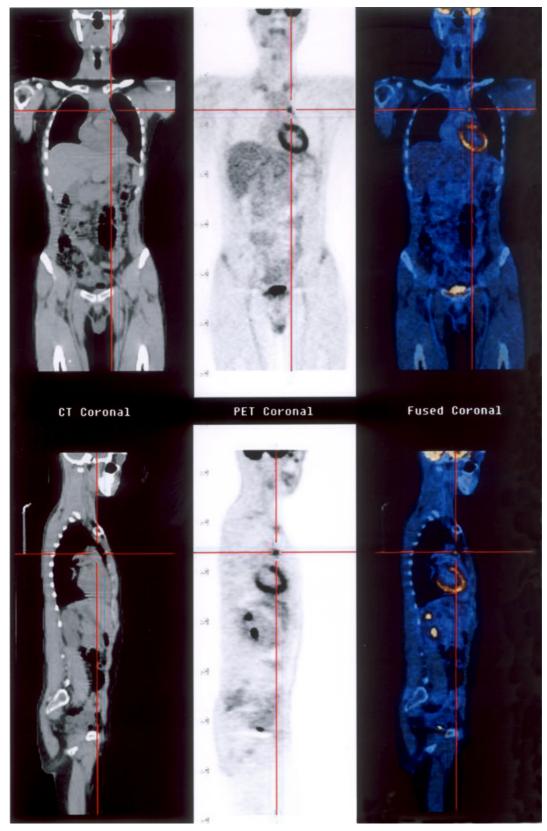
Positron emission tomography/computed tomography (PET/CT) scanning with ¹⁸F-fluoro-deoxyglucose (FDG). Coronal (above) and sagittal (below) tomographic images of non-enhanced CT, FDG PET, and fusion of CT/PET image data sets are shown in a 50-year-old male with recurrent lung carcinoma involving a <1 cm sized malignant lymph node in the anterior mediastinum marked by cross hairs on all three sets of coronal
